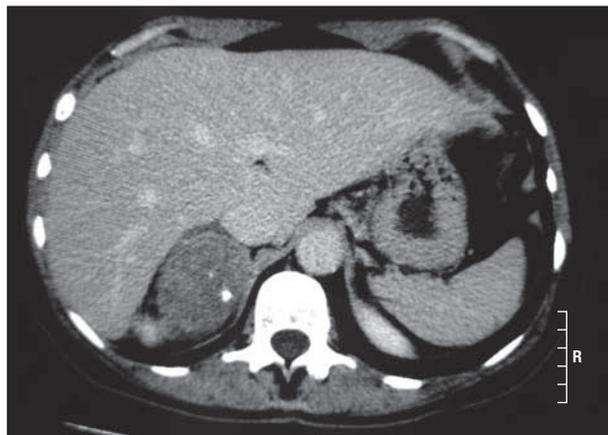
Computed tomographic scan confirmed the presence of a 7-cm inhomogeneous mass with calcifications, arising from the right adrenal gland.
